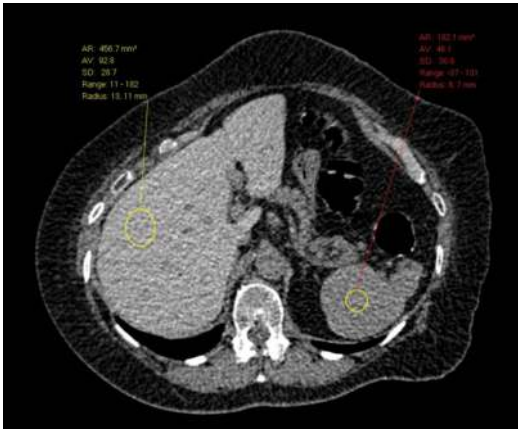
Axial unenhanced CT in a 70-year-old lady demonstrating hyperattenuating liver secondary to amiodarone. The average liver attenuation was 92.8 HU (normal 55 HU)
